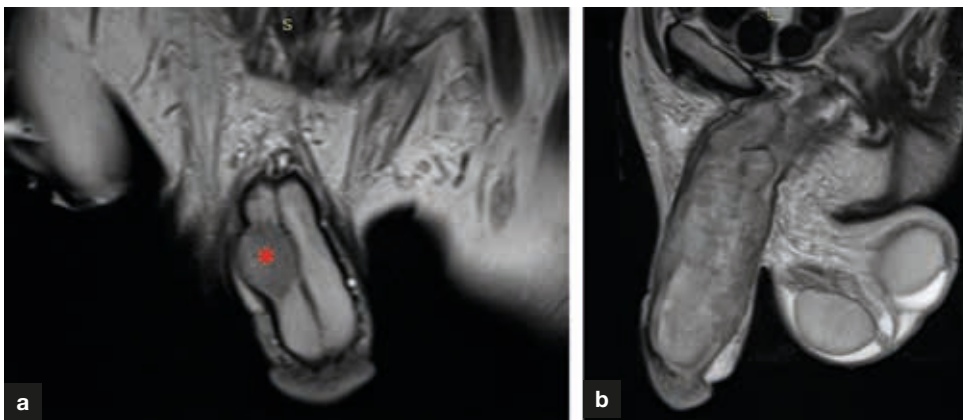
a. At presentation, coronal T2-weighted penile magnetic resonance scan shows a nodular lesion (asterisk) on the right corpus cavernosum. b. At follow up, sagittal T2-weighted magnetic resonance image shows a diffuse penile metastasis.
